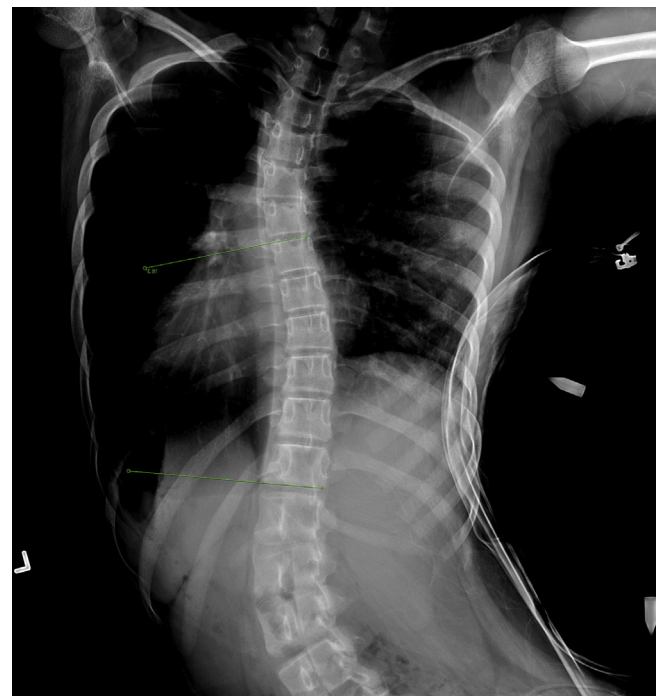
Pre-operative standing posteroanterior x-ray of the whole spine which showed a thoracic curve (T6-11) of 43° and lumbar curve (T11-L4) of 51°.
